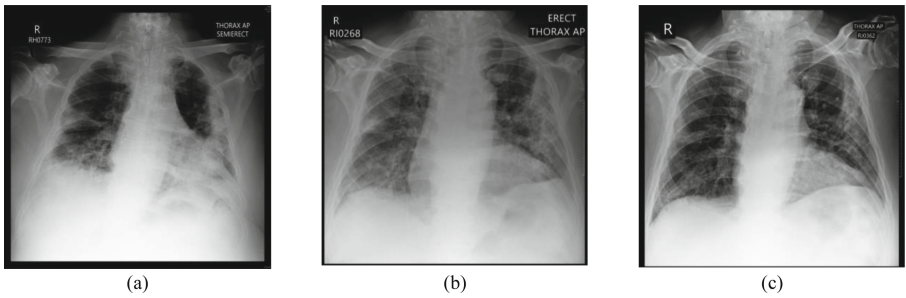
Case 2. (a) first thorax radiograph. (b) after 14 days of secretome last injection. (c). 1 month after last secretome injection.
